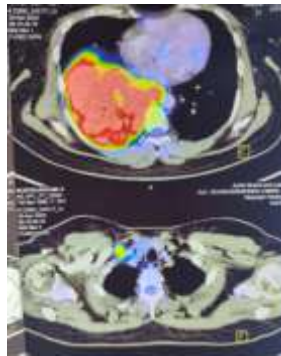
PET-CT (30 April 2024) showing FDG-avid nodules in right lower lobe.
